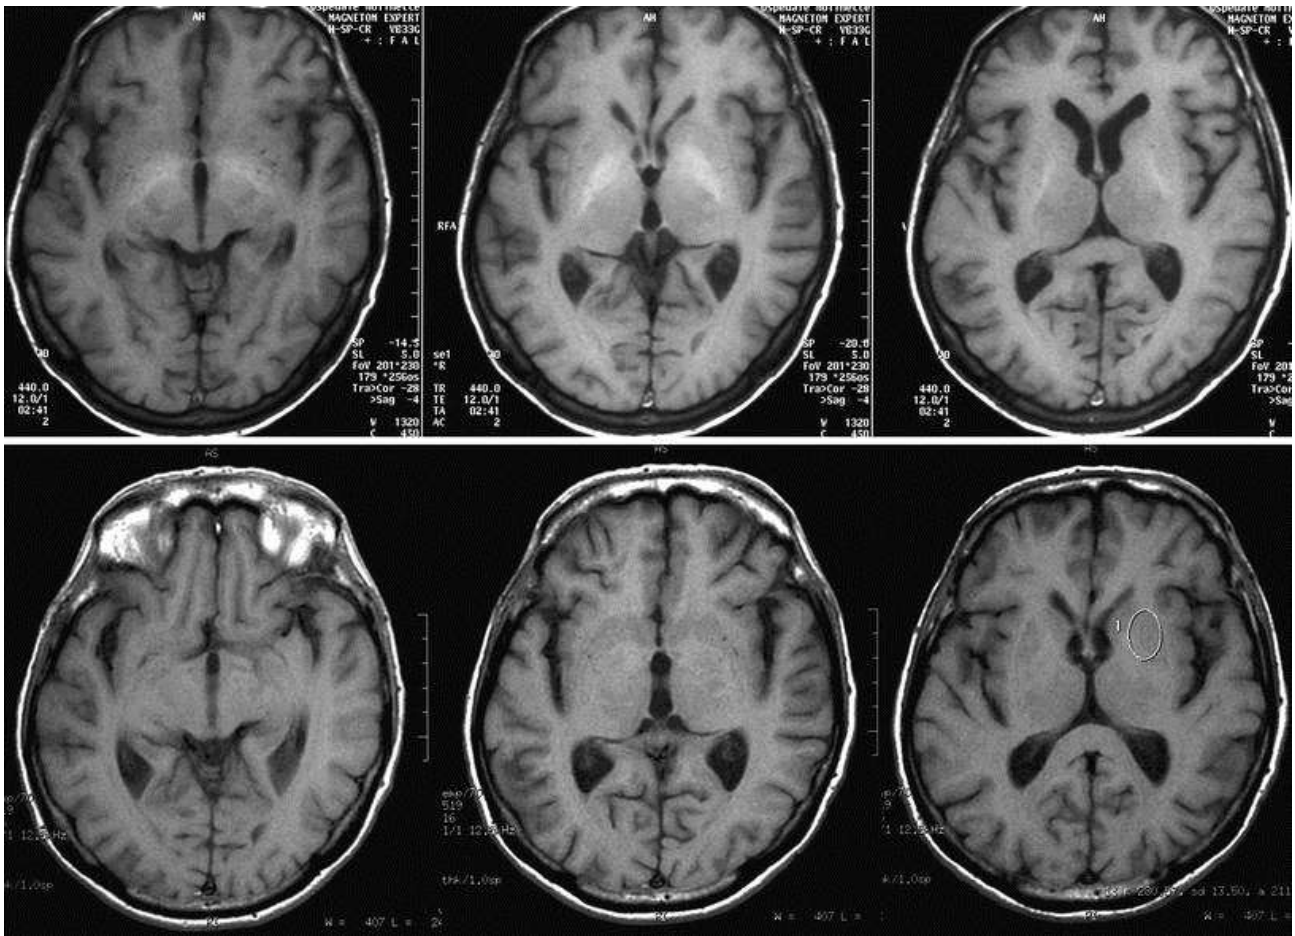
T1-weighted brain MRI of Patient 4, before OLT (*upper images*), and 9 months after OLT (*lower images*).
